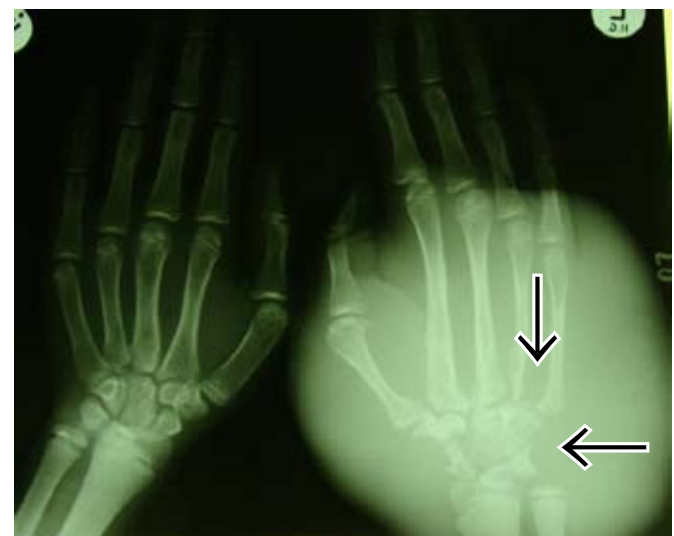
Frontal X-ray of the hands showing large plexiform neurofibroma causing focal enlargement, elongation, thinning of the metacarpals and pressure changes (scalloping) of the bases of the metacarpals and carpal bones, also called a pachydermatocoele.
